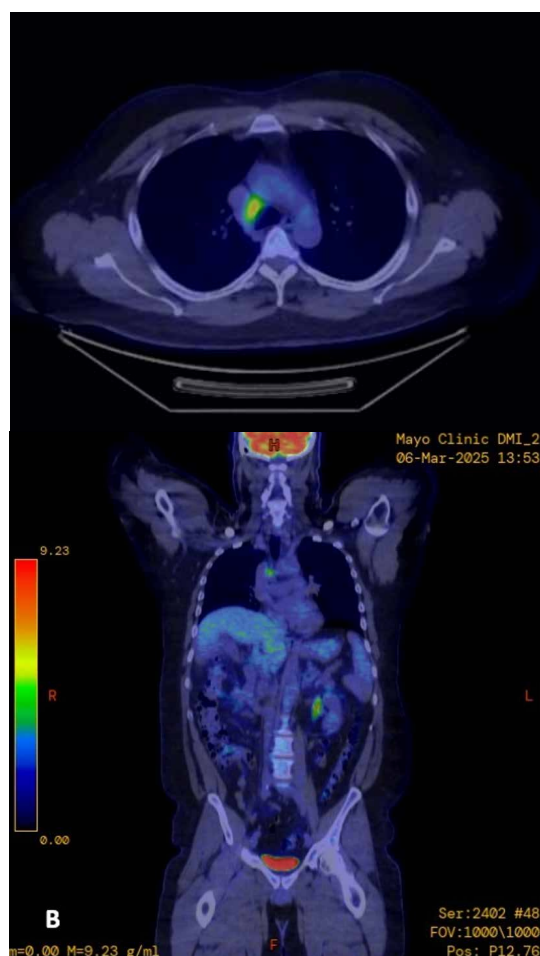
FDG-PET/CT comparison after antifungal treatment for coccidioidal lymphadenitis. Follow-up FDG-PET/CT after completion of a 3-month course of fluconazole. There is interval decrease in both size and metabolic activity (SUVmax from 15.5 to 8) of the right paratracheal lymph nodes, consistent with treatment response. Yellow arrows indicate the dominant right paratracheal lymph node conglomerate on each study.
